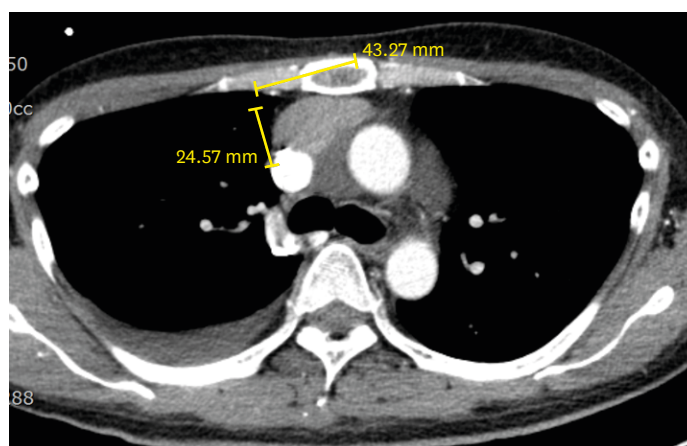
Chest computed tomography in the 7th year after the first hospital visit revealed anterior mediastinal lymph node enlargement.
